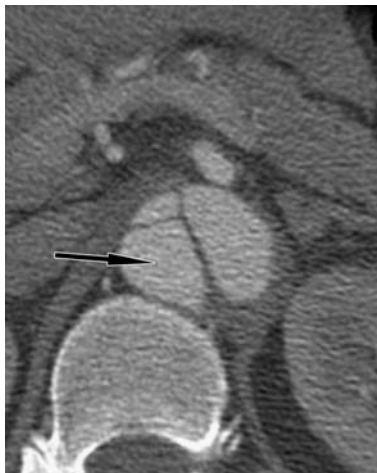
Axial contrast-enhanced CT image of complex dissection flap with two false lumens visualized. The arrow indicates the true lumen.
